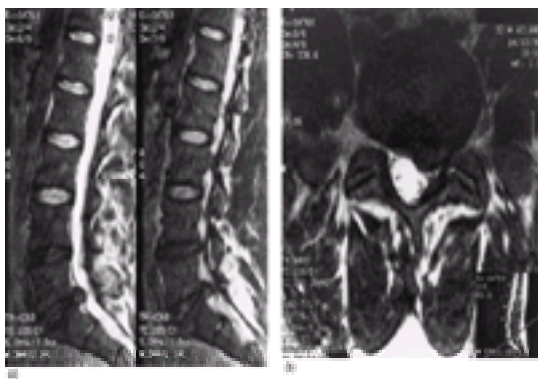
MRI: sagittal (a) and axial (b) views to show a lumbar disc prolapse.
